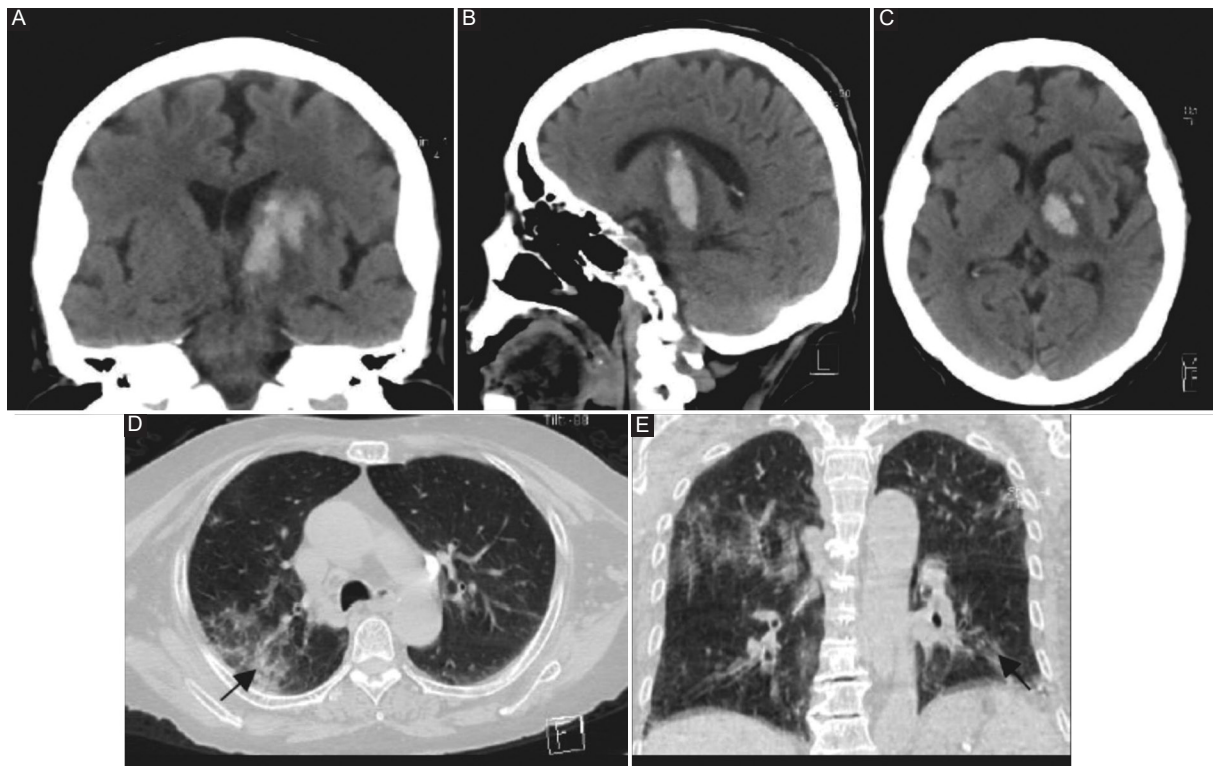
A-F: CT and X-ray examinations of brain and chest of patient 3. A-C: multiplanar reconstruction of brain CT showing right thalamic hemorrhage and presence of ventricular disruption. D: 3D reconstruction of pulmonary parenchyma showing bilateral alveolar infiltrates. E: High-resolution chest CT with lung parenchymal window, axial section showing a slight increase in density, corresponding to a frosted glass pattern, predominantly basal and peripheral bilaterally. F: chest radiograph showing bilateral ground frosted glass pattern areas predominantly in both lung bases.
